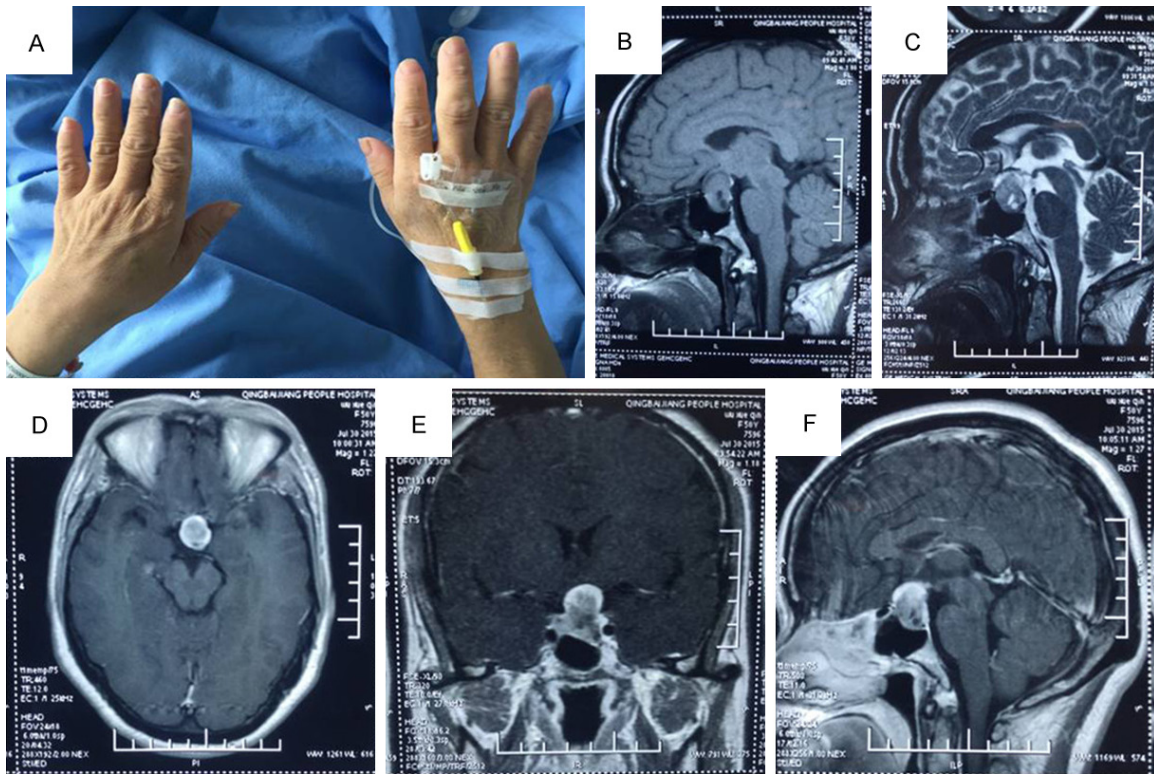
Physical examination found thick fingers with enlarged interphalangeal joints on the both side (A); MRI revealed a slightly T1-hyperintense and T2-hypointense mass with T2-hyperintense in its center (B and C); CE-MRI disclosed a sellar obviously enhancing mass about 2.1×1.9×1.8 cm after gadolinium administration which had a circular boundary and push the optic chiasma to the upward side (D-F).
